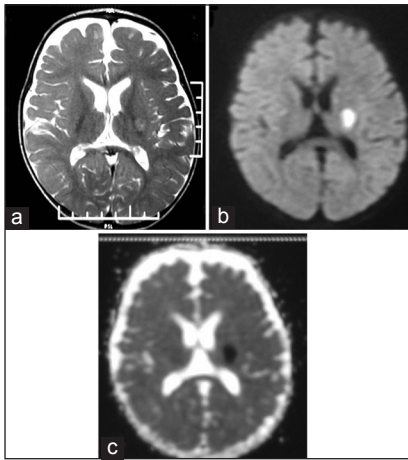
(a) T2-weighted axial MRI image shows left lentiform hyperintensity which showed restricted diffusion on diffusion weighted images (b) and hypointensity on ADC maps (c) GRE sequences and MR angiography were normal (not shown). MRI = Magnetic resonance imaging, ADC = apparent diffusion coefficient
